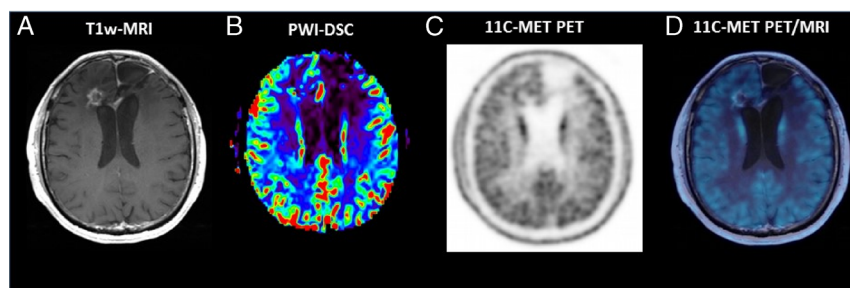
An MRI study performed after 2 years of disease stability showed the appearance of partial frontal lesion increment with areas of high perfusion. A ^{11}C -methionine (^{11}C -MET) PET/MRI was performed as per clinician's indication to better characterize the MRI finding. MR images showed partial frontal lesion increment (A) with areas of high perfusion (B) similar to the aforementioned MRI; no ^{11}C -MET radiotracer uptake (C, PET image; D, simultaneous PET/MR image) was detected; therefore, no evidence of disease was diagnosed on PET images. Contrast-enhanced MRI is the criterion standard morphological techniques for investigating high-grade gliomas.^{1,2} Hypoxia and amino acid PET imaging are complementary to MRI, underlying the multitracers capability of PET in assessing different metabolic pathways, thus providing a detailed characterization of high-grade gliomas, especially in complex cases. As hypoxia hampers the sensitivity to radiochemotherapy, ^{18}F -FAZA can be of support by detecting intratumoral areas more resistant to treatment and therefore more inclined to recurrence^{3,4}; in addition, it might improve the discrimination between radionecrosis and recurrence.^{5,6} ^{11}C -MET is used during diagnosis to identify more aggressive tumors and during therapy monitoring by supporting MRI in differentiating areas of altered perfusion because of recurrence/progression or not.⁷ Simultaneous PET/MRI scanners offer the possibility to integrate morphological and functional information in a single session examination, thus resulting in a diagnostic improvement for both patients' comfort and clinical information.⁸
